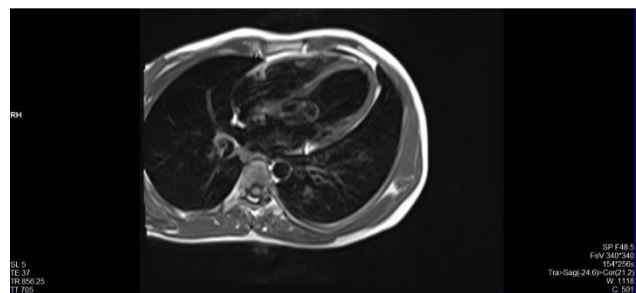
Cardiac magnetic resonance image shows blood cyst
